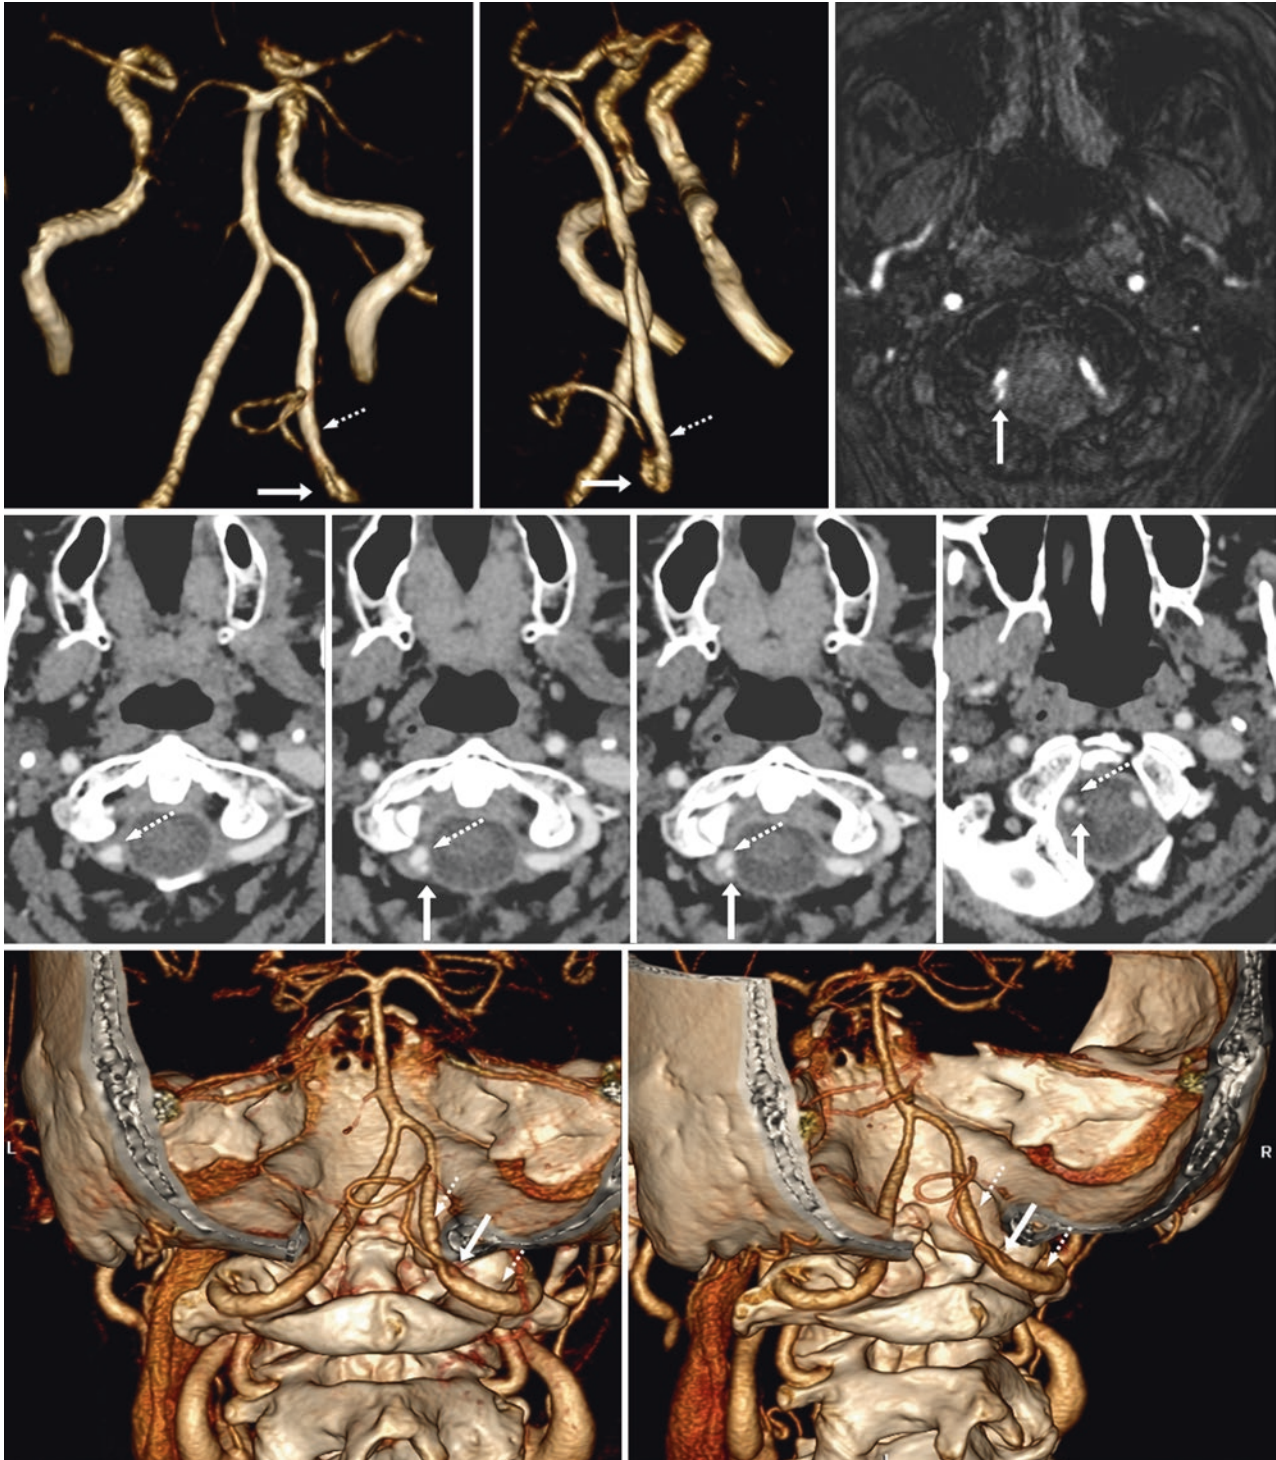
76-year-old with dizziness. *Top row:* 3D TOF MRA PA view (*left*) and right lateral view (*middle*) show a low origin of the right PICA (*arrows*) from the right VA (*dotted arrows*), also visualized on source MRA images (*right*). *Middle row:* CTA source images confirm
